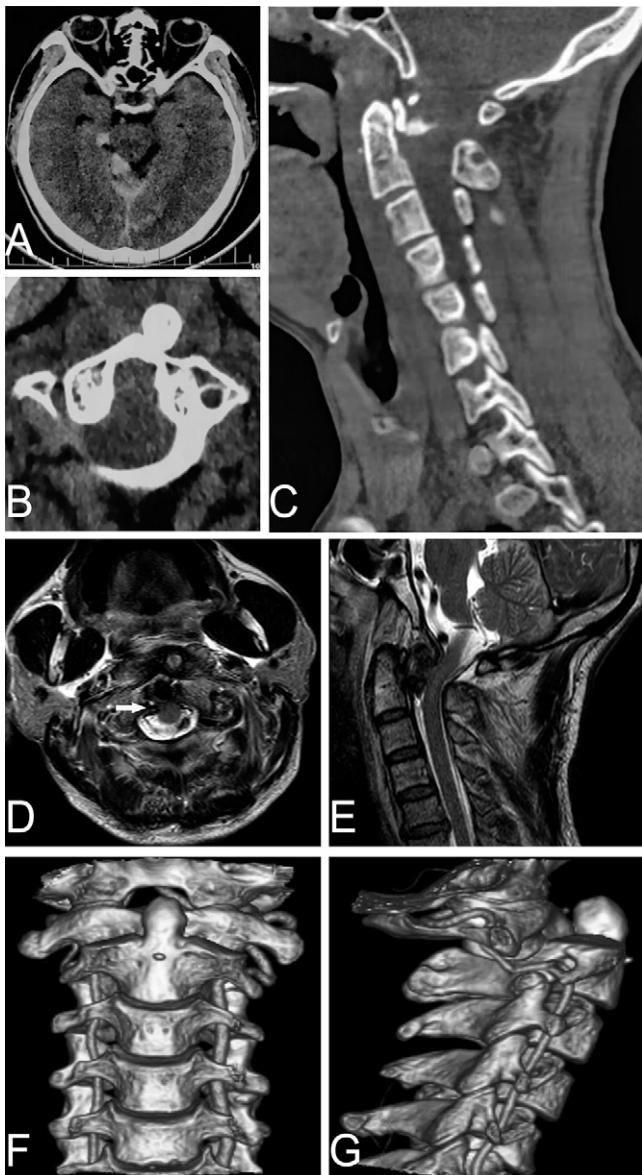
CT showed intracranial subarachnoid hemorrhage (A) and ventral translocation of the odontoid process but without fractures (B and C). MRI (D and E) revealed an avulsion of the transverse ligament (white arrow) and deviation of the neural axis with no intramedullary signal change. Three-dimensional CT angiography confirmed that the right vertebral artery was strained and angulated (F and G).
